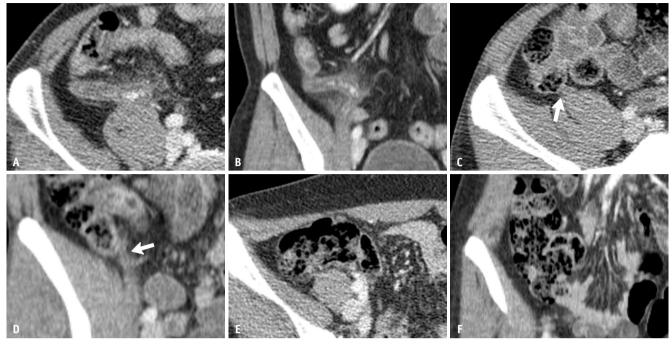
Representative cases of appendiceal visualization on 2-mSv CT.
